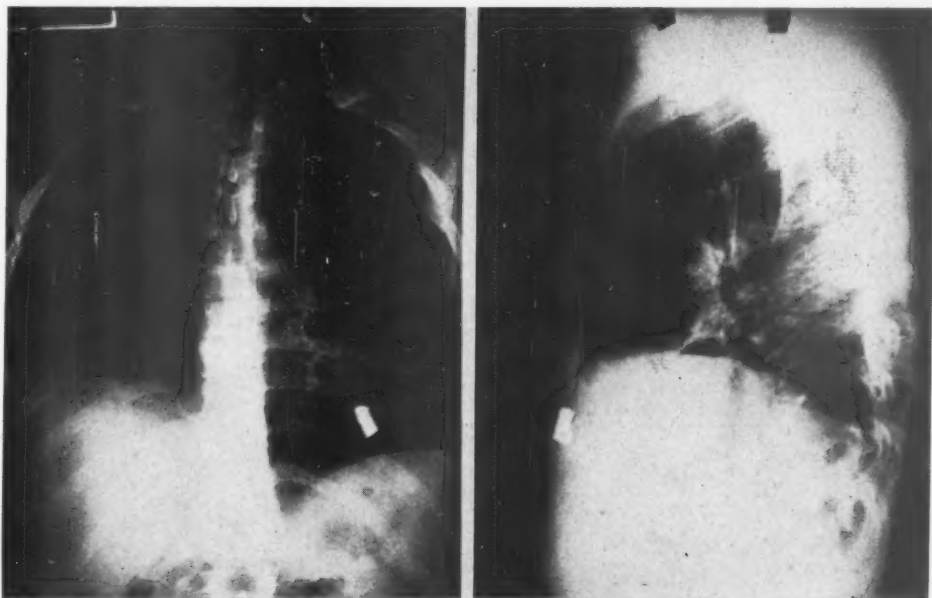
Posteroanterior and lateral roentgenograms of the fragment again in the right ventricle after the second unsuccessful cardiotomy.
